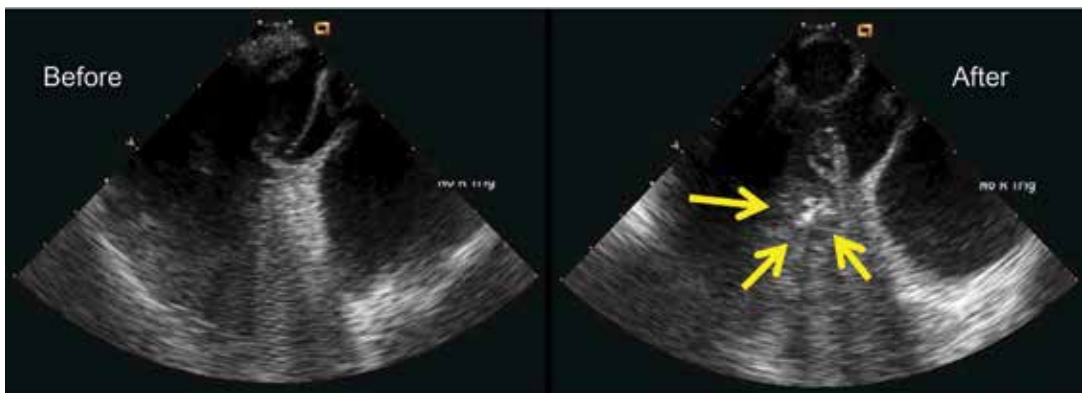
Intraprocedural imaging of lesion formation with intracardiac echocardiography (ICE). Effective lesion formation is associated with increased echogenicity of the myocardium, which has been shown to correlate with lesion size at pathology in preclinical studies.⁶⁷
